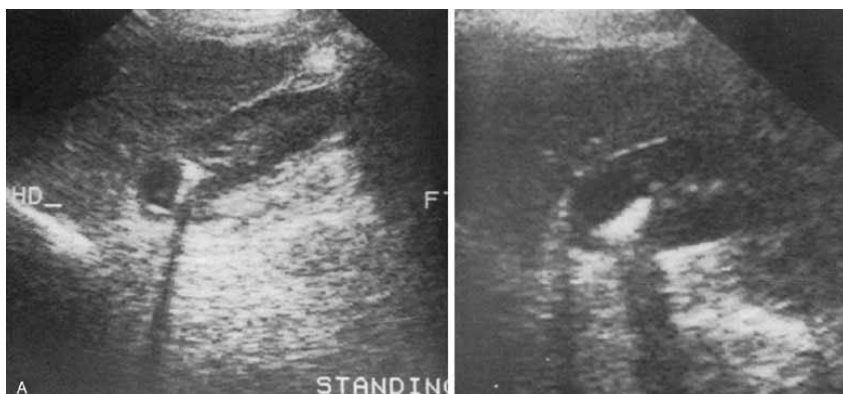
Ultrasound scan of kidney stone, (sitting and standing position)
